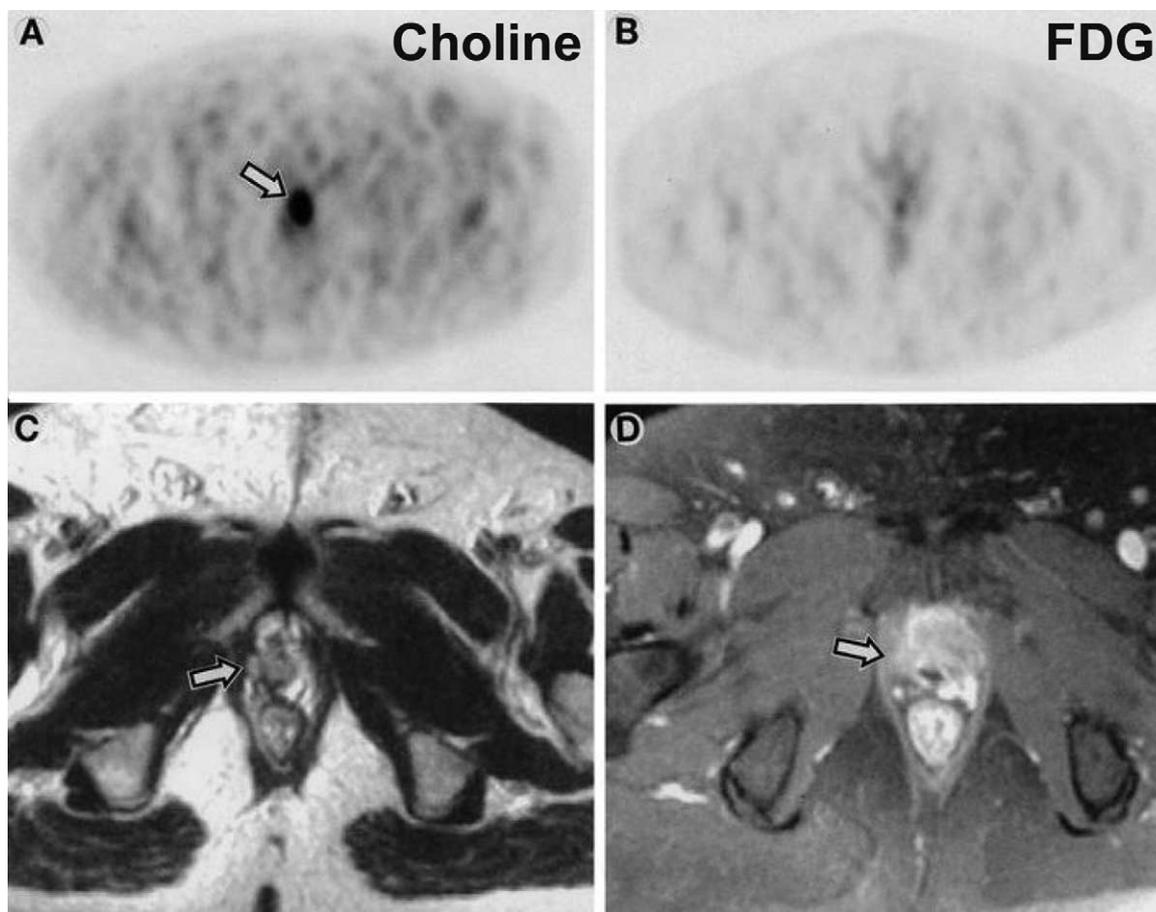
Transaxial PET images in a patient with a man with PSA relapse (PSA = 3.8 ng/mL) approximately 6 years after radical prostatectomy. ^{11}C choline PET shows abnormal tracer accumulation in the prostate bed (A), whereas FDG image appears normal (B). T₂-weighted spine-echo MRI (C) and contrast-enhanced, fat-suppressed T₁-weighted MRI (D) clearly show abnormal soft tissue in the prostate bed (arrows). (Images used with permission from Picchio et al. *J Urol* 169:1337-1340, 2003.)
